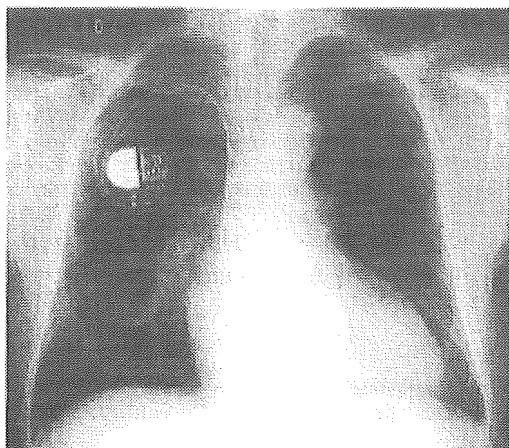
Chest X-ray film before left ventriculoplasty (Batista operation), showing cardiomegaly and pulmonary congestion. Bilateral hilar lymphadenopathy is not apparent.
